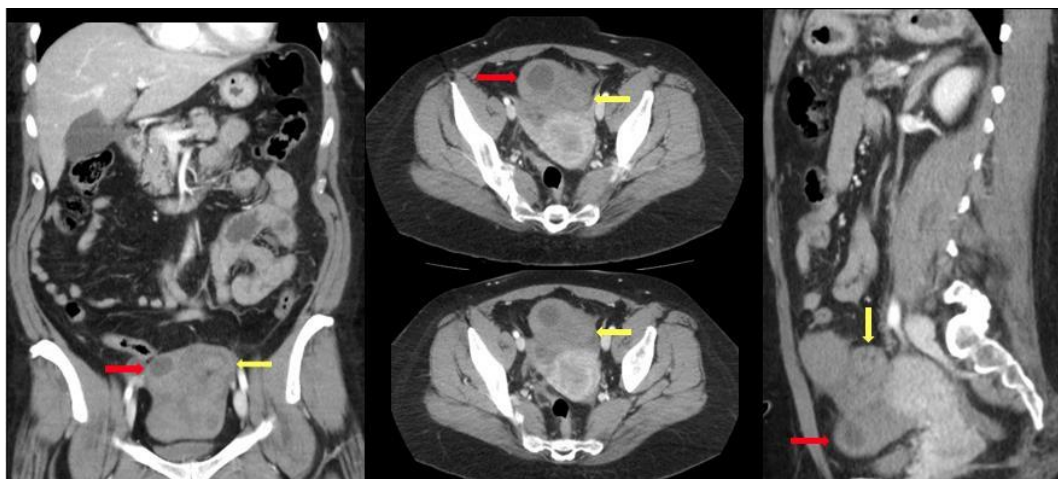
Abdominopelvic contrast CT revealed, high density free liquid compatible with hemoperitoneum. In the adnexal region an image of soft tissue density with cystic formations inside (red arrow), incurvation of the vascular pedicle "swirl or twist sign" (yellow arrow), compatible with ovarian torsion with underlying cystic lesion.
